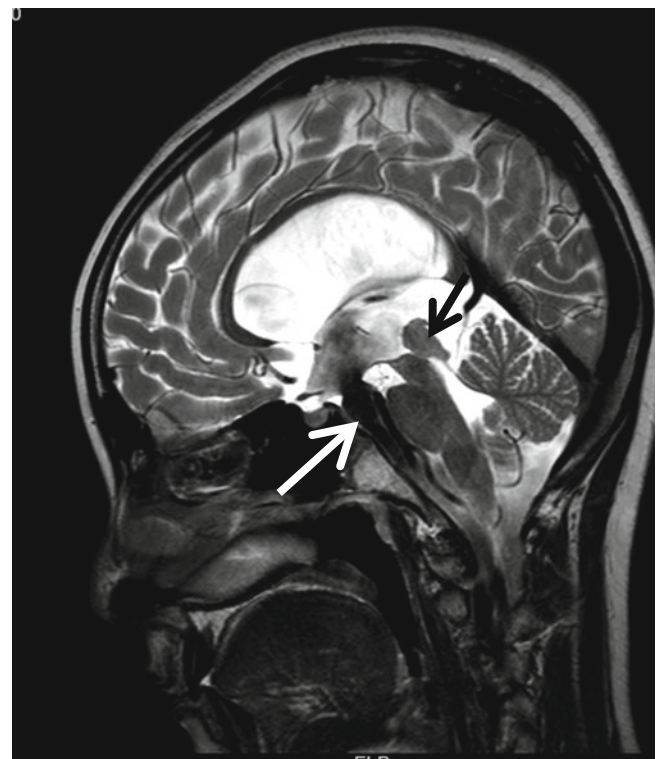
Tectal glioma causing hydrocephalus in a 10-year-old boy who underwent endoscopic third ventriculostomy. T2-weighted sagittal image shows enlarged midbrain tectum (black arrow) causing aqueductal obstruction. Prominent flow artifact is noted (white arrow), suggesting patent defect at the floor of the third ventricle
